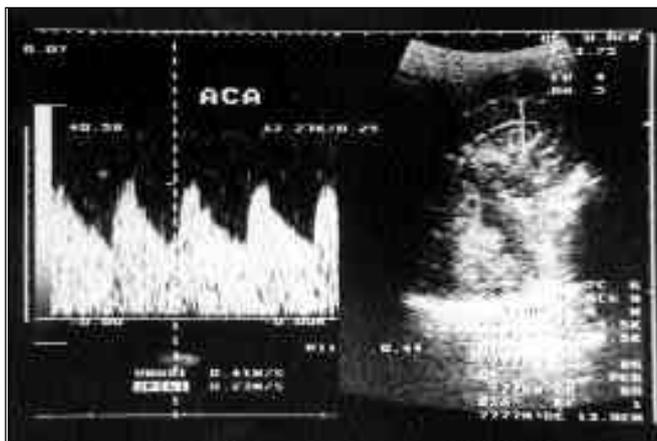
Transcranial duplex Doppler ultrasonography demonstrating a low resistance pattern of the anterior cerebral artery (ACA) in an asphyxiated infant.
